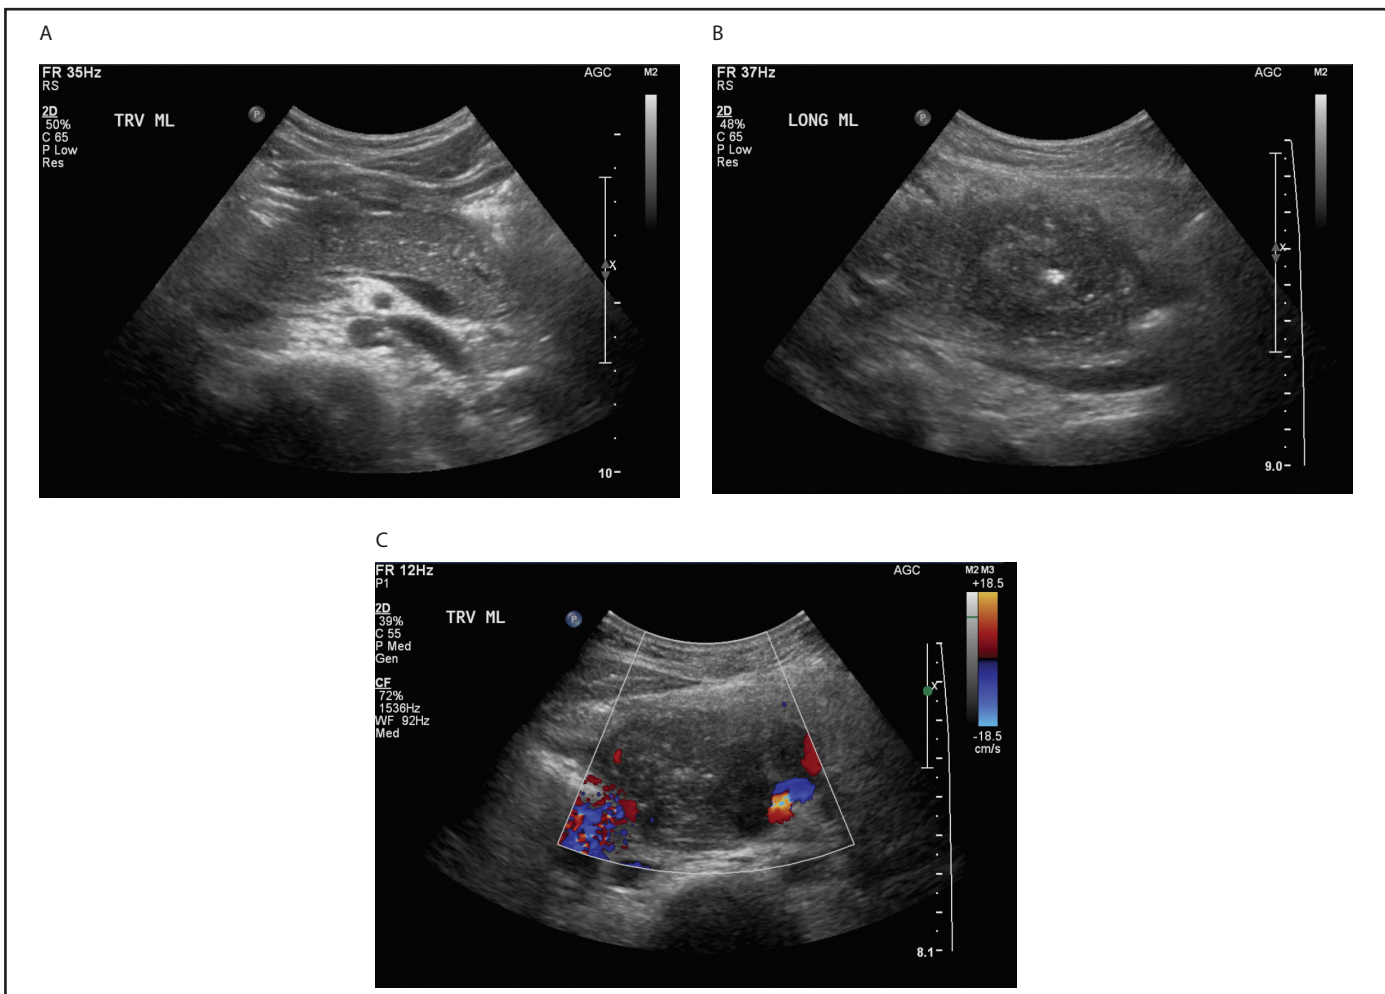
Week 68. (A) Transverse: Heterogeneous pancreatic parenchyma with the prominent pancreatic duct. (B) Sagittal: Pancreatic head lesion; ill-defined with a central echogenic area. (C) Sagittal: Colour Doppler shows peripheral vascularity with no echogenic foci seen within the lesion.
